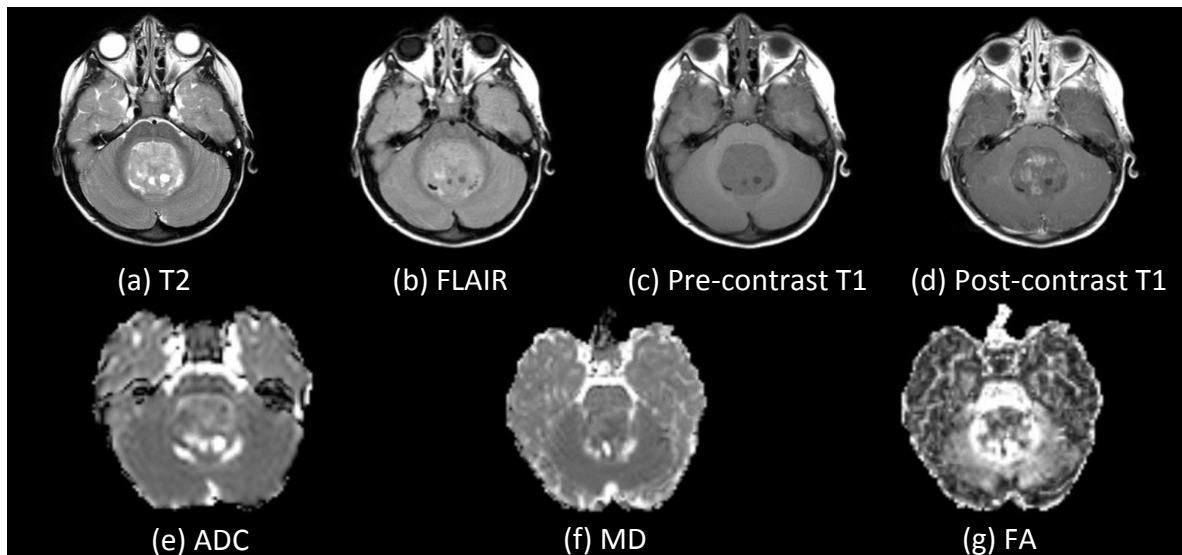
Imaging characteristics of a medulloblastoma based on T2, FLAIR, pre-contrast T1, post-contrast T1, ADC, MD and FA (case MB719).
